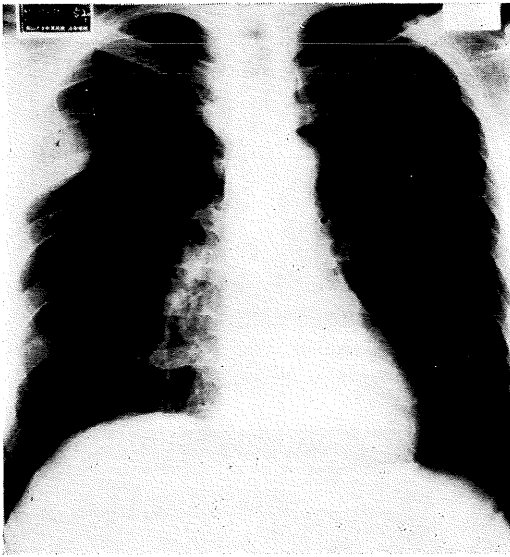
Chest radiograph showing a discrete tumor protruding to the right upper field of the lung.
